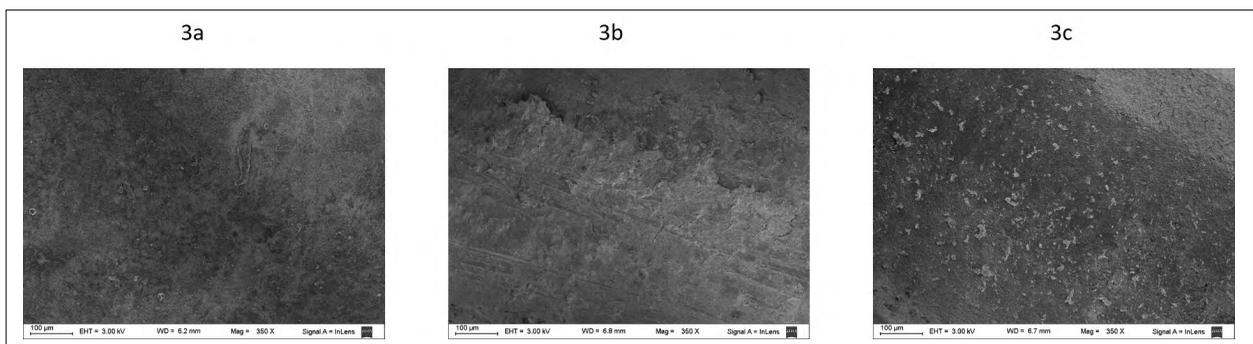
Scanning electron microphotographs (350X) for observation of secondary smear layer removal in Group PIU (passive ultrasonic irrigation). a: cervical third, there is a thick, even smear layer completely covering the dentin surface. b: middle third, scratches on root canal walls. c: apical third, with persistence of a thin smear layer and a few small debris particles, approximately 20µm across, scattered over the surface.
